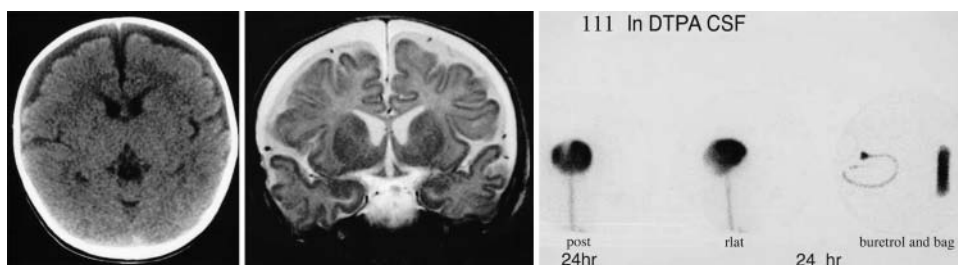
Case 2. *Left:* Axial CT scan obtained in a boy with lethargy and poor oral intake, showing hypodense extraaxial fluid collections bilaterally over the frontal lobes. *Center:* T₂-weighted coronal MR image revealing bilateral parasagittal subdural collections and arachnoid membrane detached from the sagittal sinus. *Right:* Nuclear medicine ventricular cisternogram obtained 24 hours after intrathecal ¹¹¹In DTPA injection demonstrating flow of radioisotope out the subdural catheter into the collection system.
